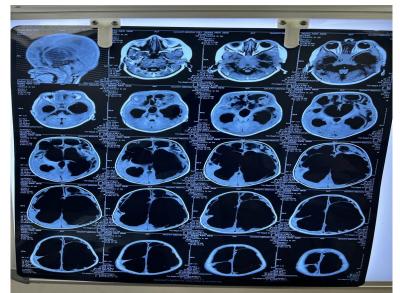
Congenital Hydrocephalus with Hypoxic Ischemic Injury (MRI Image)
